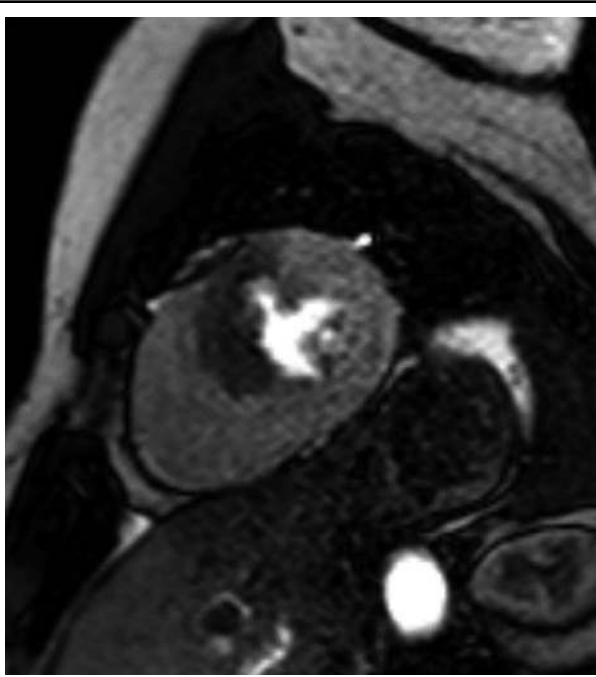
Stress myocardial perfusion MRI: short-axis view of the left ventricle. Myocardial ischemia in the anteroseptal wall associated with the left anterior descending artery stenosis is depicted as a region of low signal intensity during first-pass of contrast medium.
